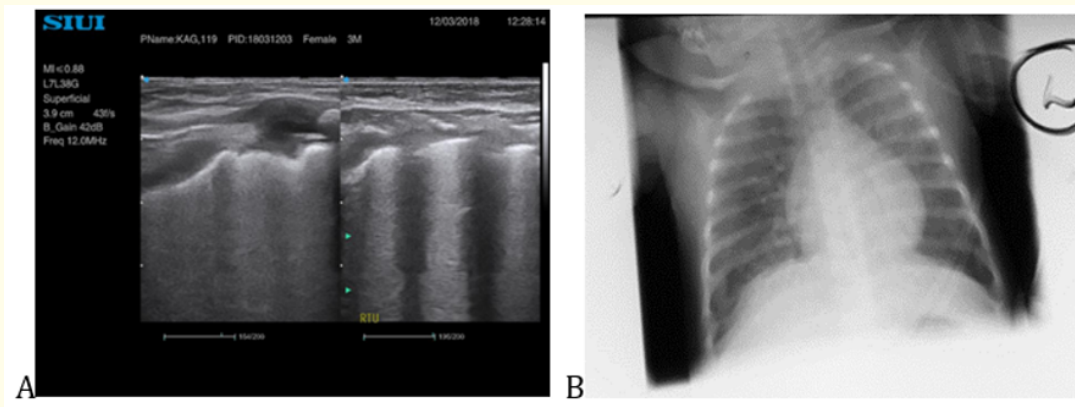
A case of interstitial disease. A 3-month-old baby admitted with severe pneumonia. A; Sonogram of the right anterior upper region showing a white lung. B; An AP chest radiograph showing bilateral ground glass opacification of both lung fields.
